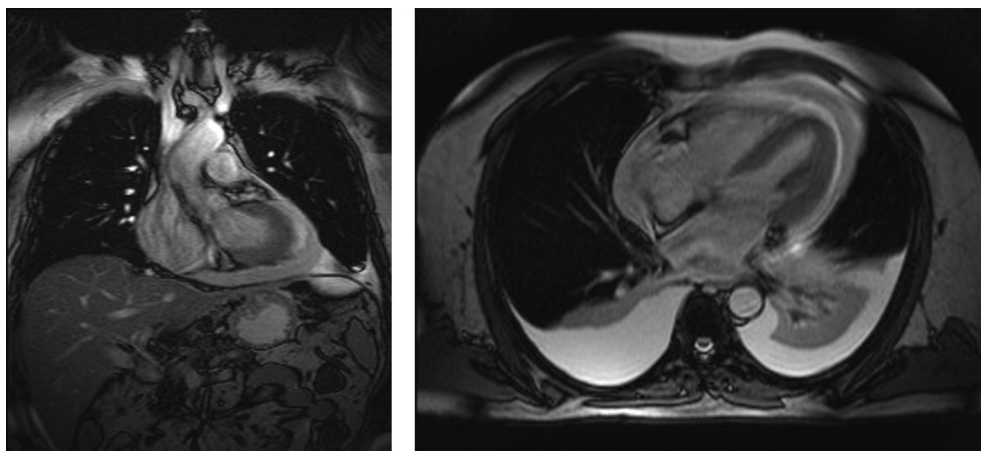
Cardiac MRI showing a large pericardial effusion.
